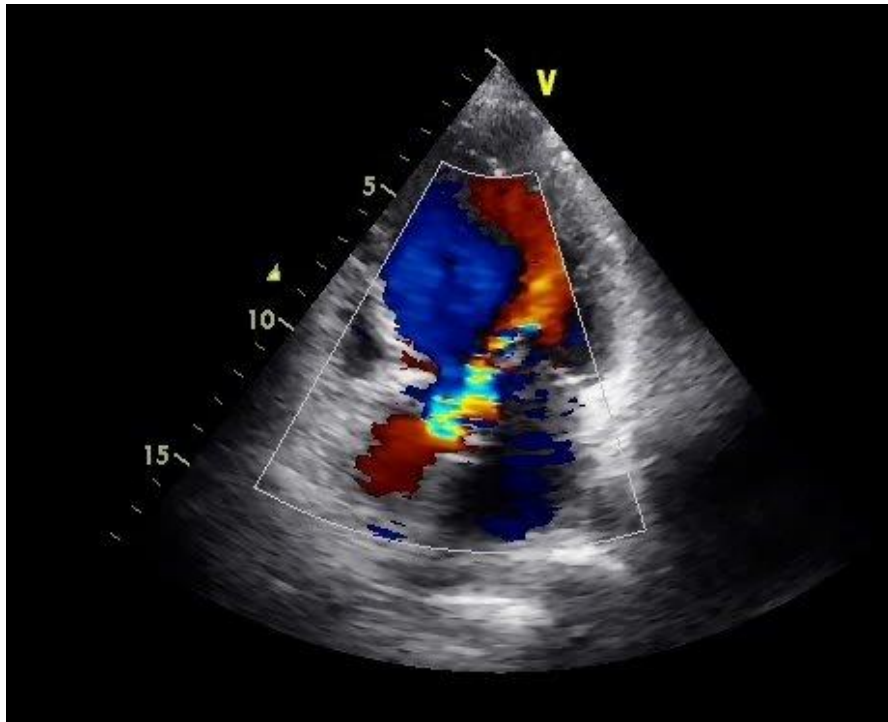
Trans - thoracic echocardiogram in apical 3 chamber view showing severe aortic regurgitation
